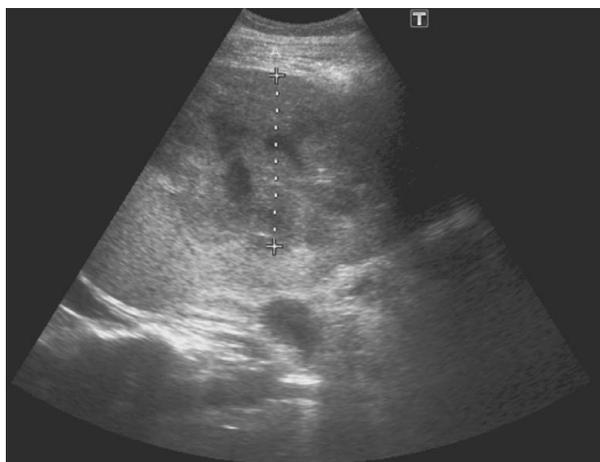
Ultrasonography of liver shows echo poor area with central areas of breakdown with peripheral enhancement suggestive of liver abscess.
